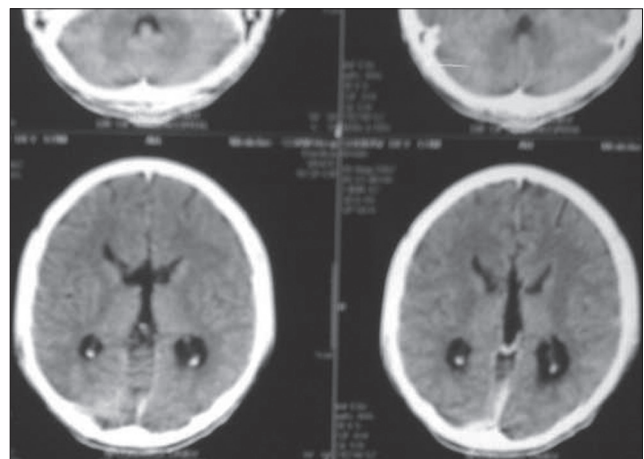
Contrast-enhanced CT scan showing parallel ventricles with continuation of interhemispheric fissure with the third ventricle; however, there was no evidence of any interhemispheric cyst
